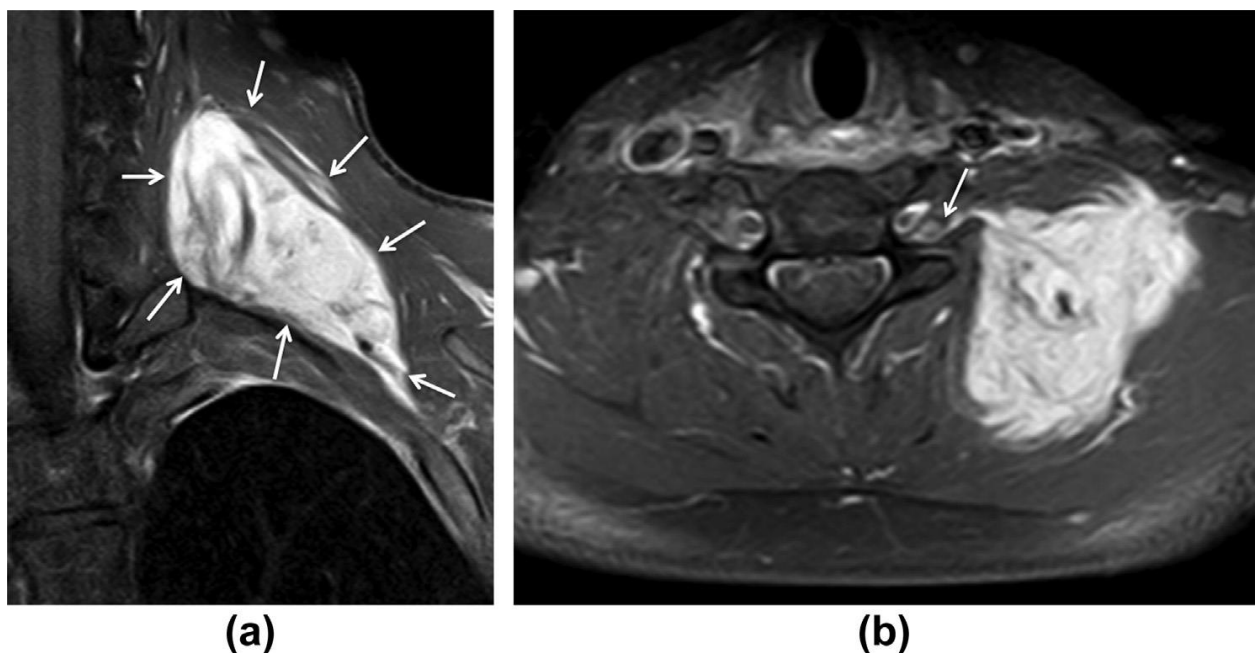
Horizontal neck fibromatosis from the left. Axial STIR MRI (b) and coronal (a) films reveal an infiltrative lesion in the left the brachial plexus area. The lesion is highlighted by arrows. The axial image shows tumor infiltration into the C7 neural exit foramen (arrow) license number 5610100806725 volume 70 [13]
